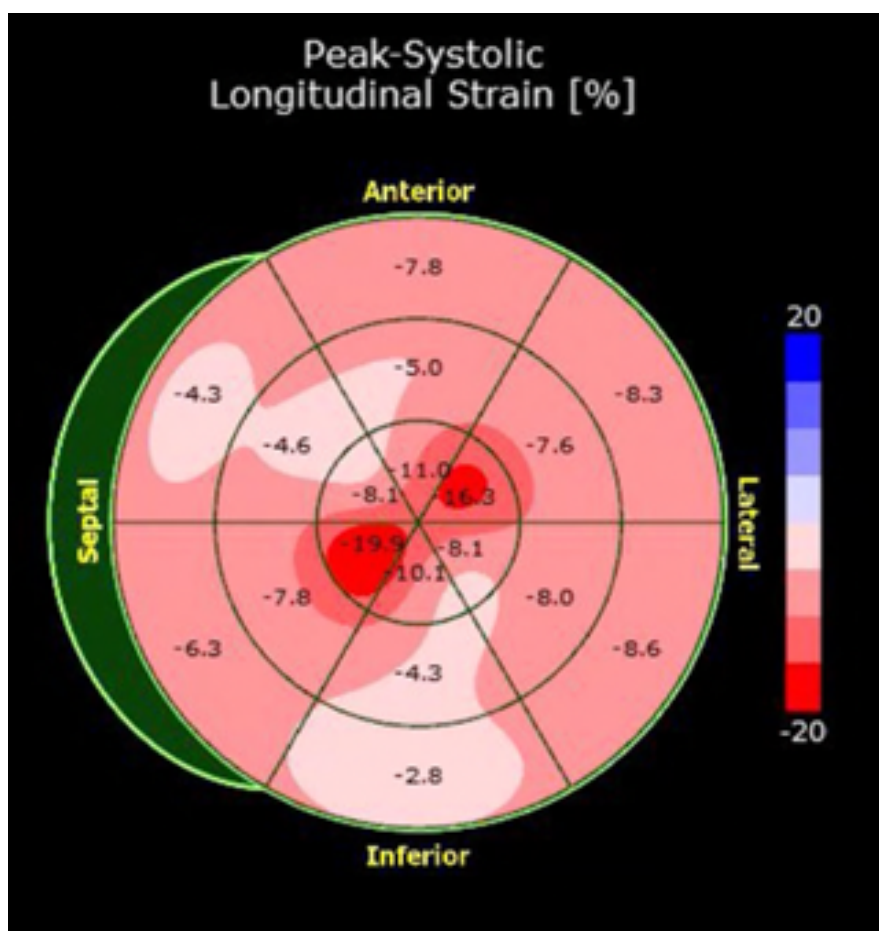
Global longitudinal strain analysis on transthoracic echocardiography demonstrating reduced overall value but with preservation of strain value at the apical region (i.e. a ‘cherry-on-top’ pattern), which commonly occurs in the context of cardiac amyloidosis.
